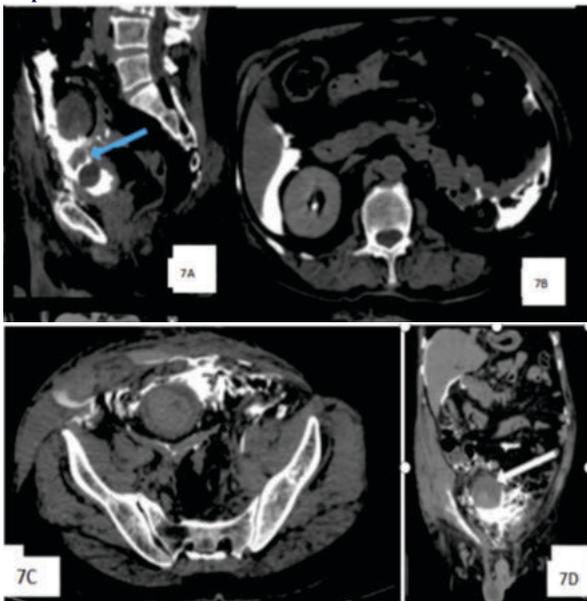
CT retrograde cystography sagittal image reveals deficient dome of the urinary bladder with intraperitoneal extravasation of contrast into the peritoneal cavity.
